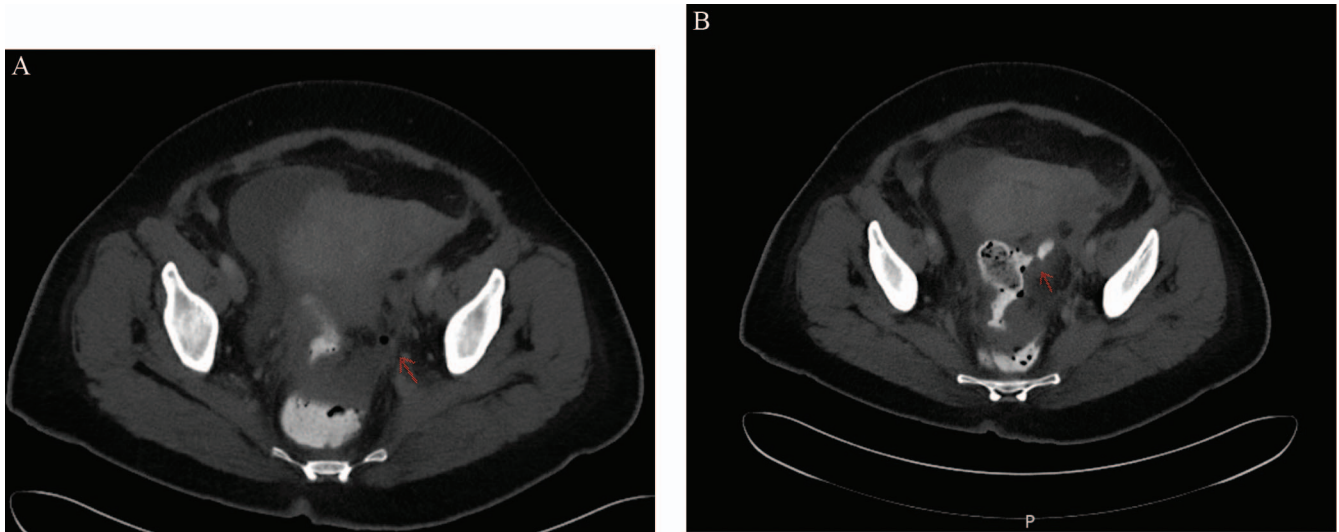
CT evidence of perforated sigmoid diverticulitis. Findings: perforated sigmoid diverticulitis, with increased inflammatory stranding and fluid in the abdomen and pelvis. A, Small amounts of extraluminal air (arrow). B, There is a 4-cm sigmoid diverticulum (arrow).
